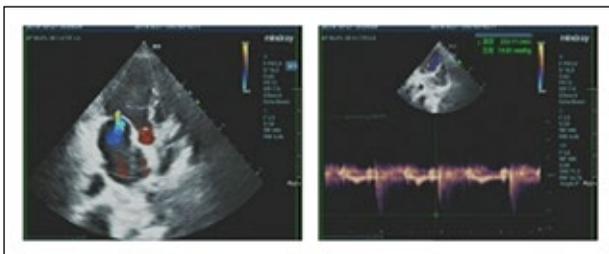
Colour Doppler echocardiography - the heart is located in the right chest cavity.
